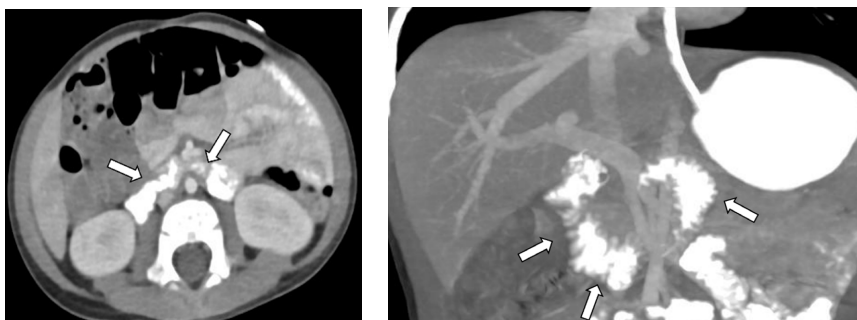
A toddler with abdominal pain underwent a contrast-enhanced CT with enteric contrast given via nasogastric tube. Left: Axial image shows enteric contrast within the duodenum as it crosses the midline (arrows). Right: Coronal maximum intensity projection (MIP) image shows the course of the duodenum (arrows).
